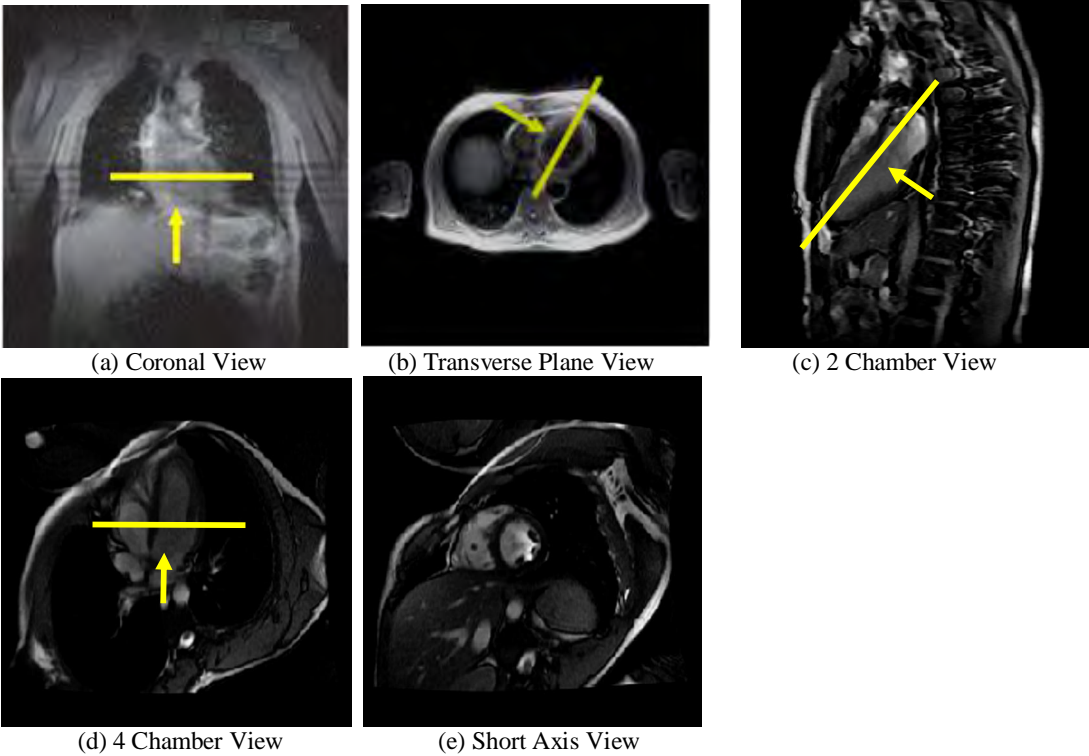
Cardiac MRI along different axes. The next image is in the direction of the cut (shown in yellow).
